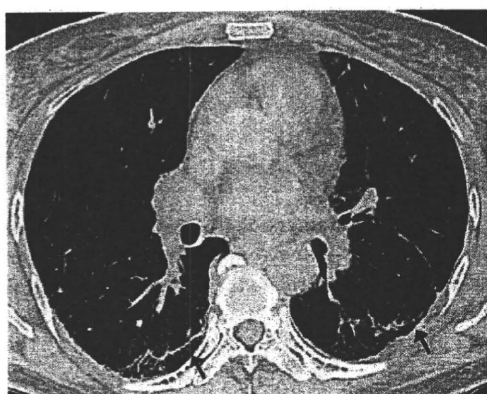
Nonspecific interstitial pneumonia (NSIP) associated with polymyositis and dermatomyositis (PM/DM) in a 51-year-old woman. Transverse thin-section CT (2-mm collimation) at the level of the inferior pulmonary vein demonstrates subpleural lines (arrows).
